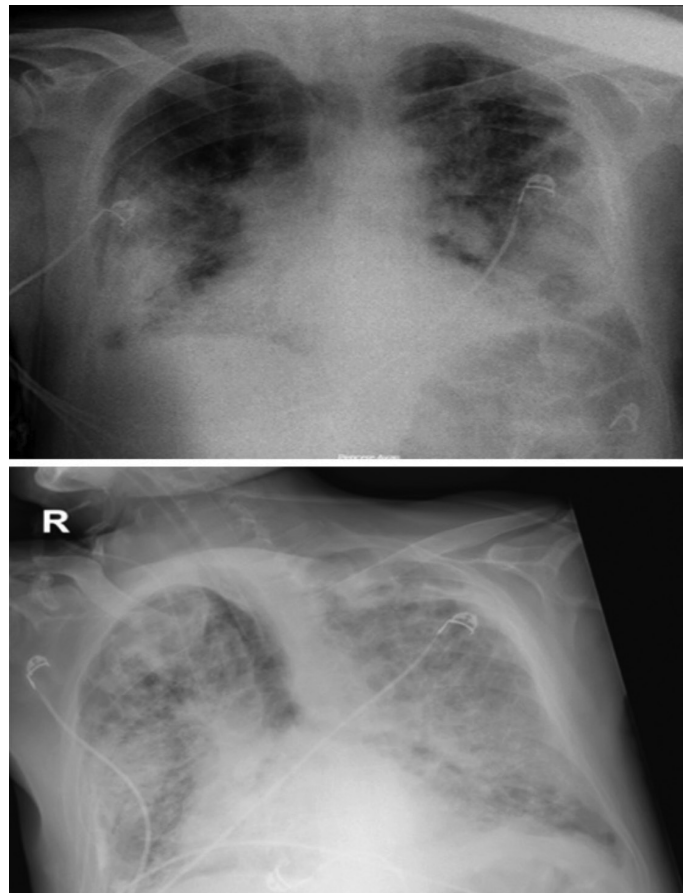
A) Admission chest X-ray demonstrating consolidations accompanying peripherally located ground glass opacities, particularly in the lower and middle zones of both lungs. B) A white lung appearance formed by mixed densities (ground glass opacities and consolidation) involving both lungs in the late stage
